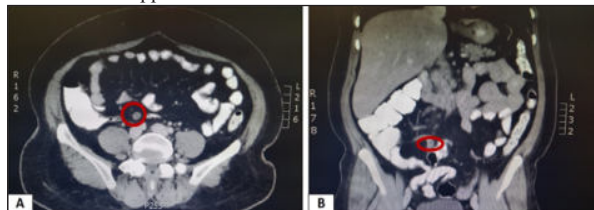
A and B: CT scan showed the well-defined low attenuated possible cystic appendiceal lesion at its tip associated with rim of enhancement (within the red circle).
